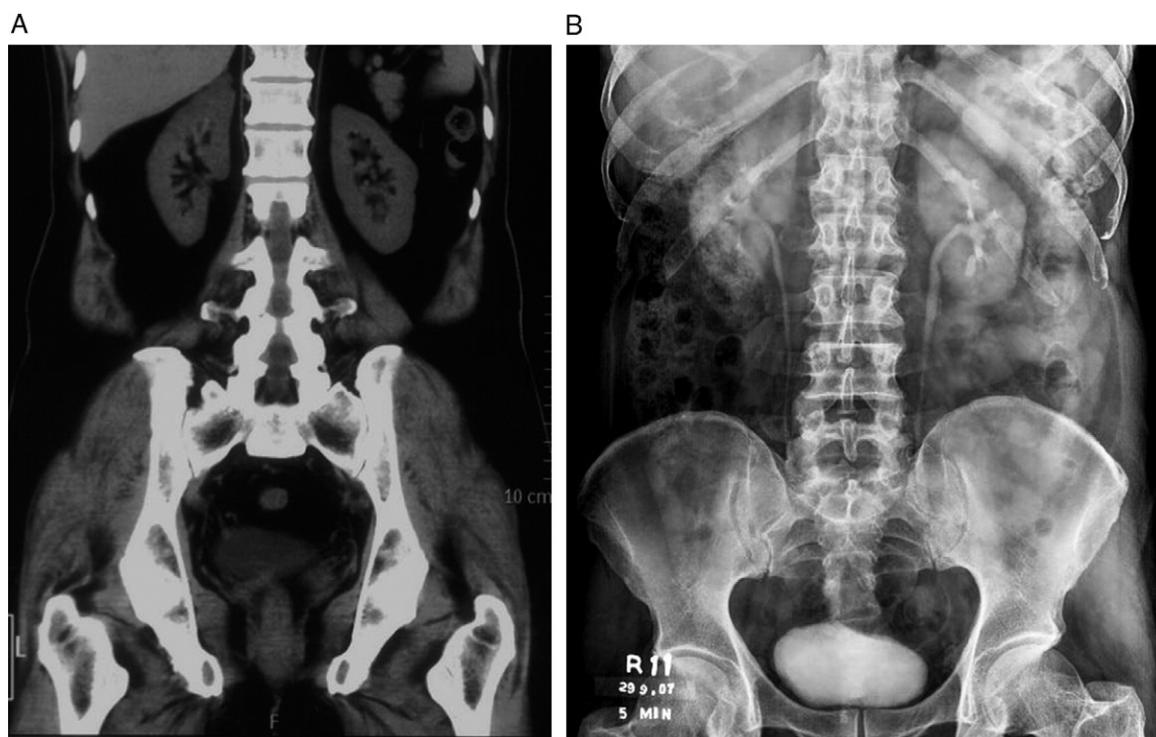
CT (A) 1 month and IVP (B) 3 months postoperatively in patient with lower pole calculus in acute angle infundibulum reveal complete calculous clearance, normal function and unobstructed drainage.
